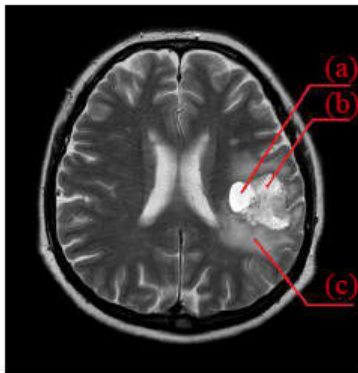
T2-weighted image showing the brain tumor. (a) Tumor. (b) Necrotic tissue. (c) Edema
